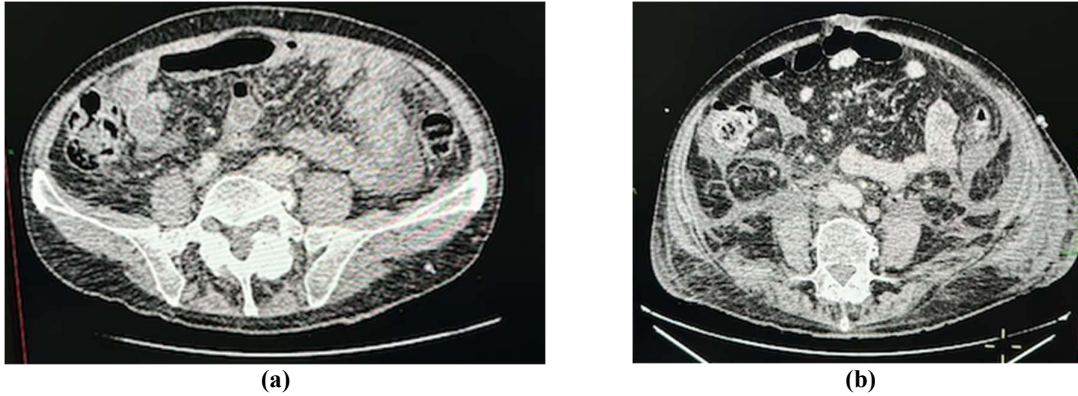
Case 1: Abdominal CT showing metastatic tumor response after NIV: Jul (left) and Sept (right).
